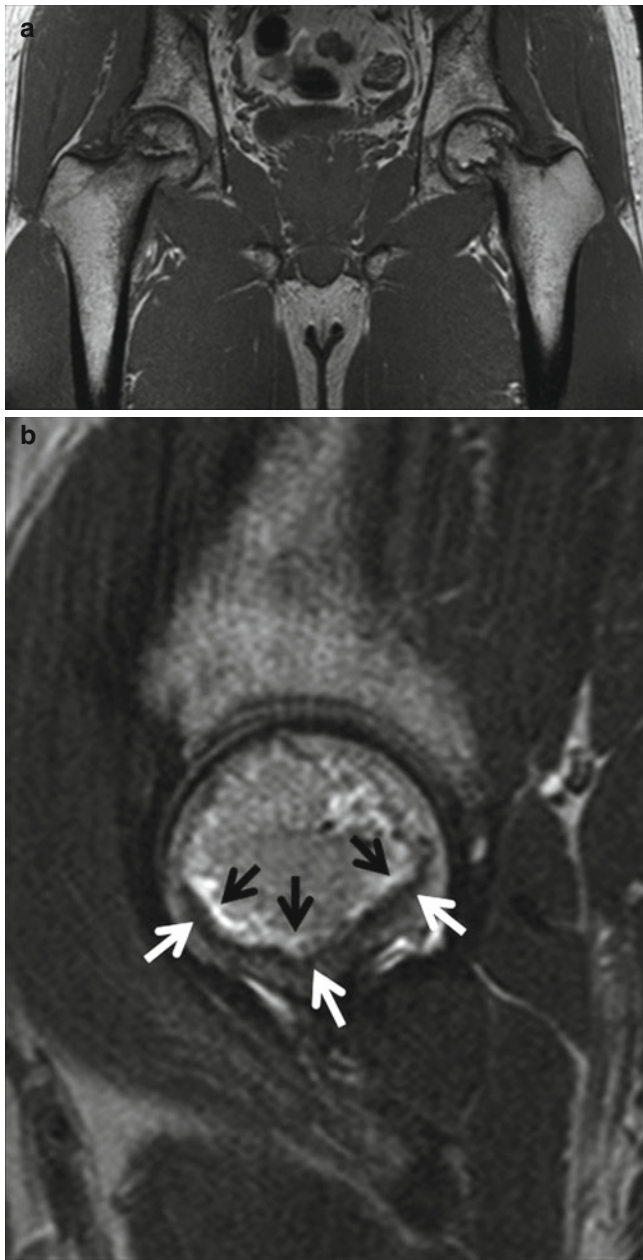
ON of both femoral heads. (a) On T1-weighted coronal MR image, circumscribed “band-like” lesions with low signal intensity are noted in both femoral heads. (b) On T2-weighted sagittal MR image of the left hip, the “double-line” sign is well noted. This sign consists of a low-signal-intensity outer rim (*white arrows*) and a high-signal-intensity inner rim (*black arrows*)
